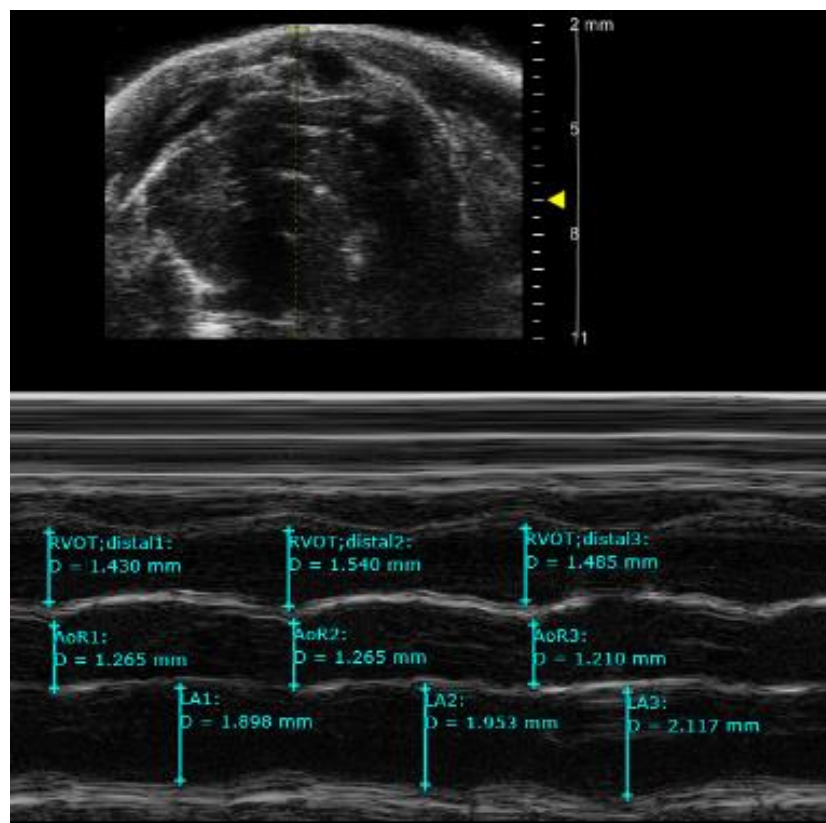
M-Mode of Parasternal short axis view, at aortic valve level.
